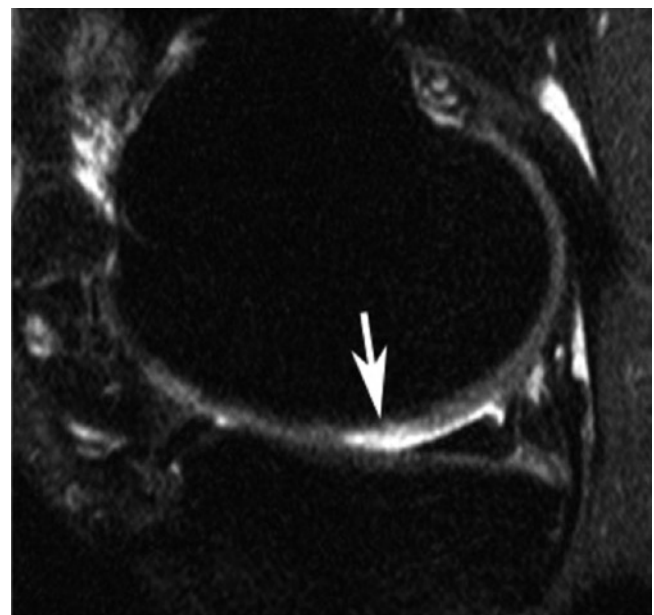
Sagittal fat-suppressed PD-weighted MRI at 1.0 T depicts a focal cartilage defect (arrow) at the central weight-bearing medial femoral condyle (Courtesy Dr. Ali Guermazi, Boston University)
